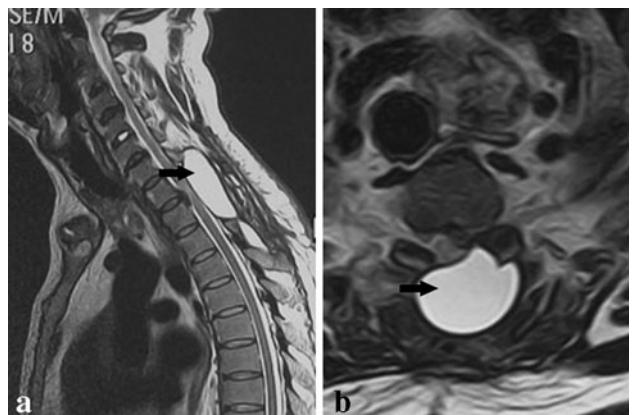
Postoperative MRI at month 6 showed residual cerebrospinal fluid at the dorsal area of the dural sac (black arrows). a Sagittal plane, b axial plane
